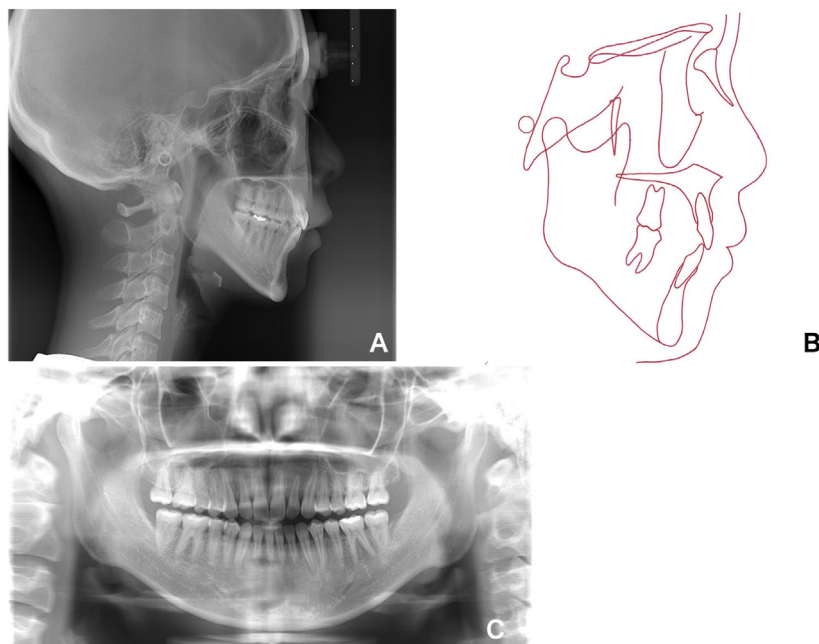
Patient 2: A-C, posttreatment cephalometric radiograph, cephalometric tracing, and panoramic radiograph.
